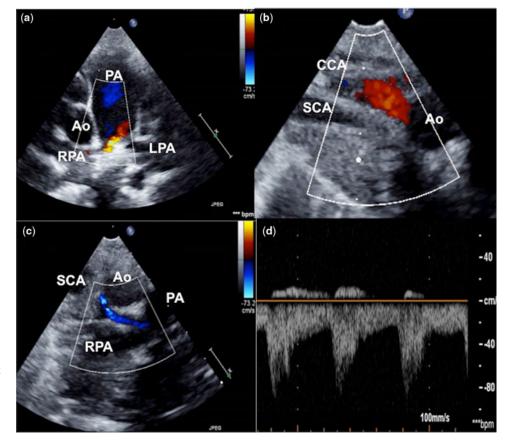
High parasternal short axis view (*a*) on echocardiogram shows a continuous flow in unusual location from the right pulmonary artery. Suprasternal view (*b*) shows the first vessel from the left arch to the right without any branching indicating that the vessel is right carotid artery. A vessel parallel to the right carotid artery (*c*) that shows flow reversal in blue colour is the isolated right subclavian artery (*d*) that connects through the duct to the right pulmonary artery.
